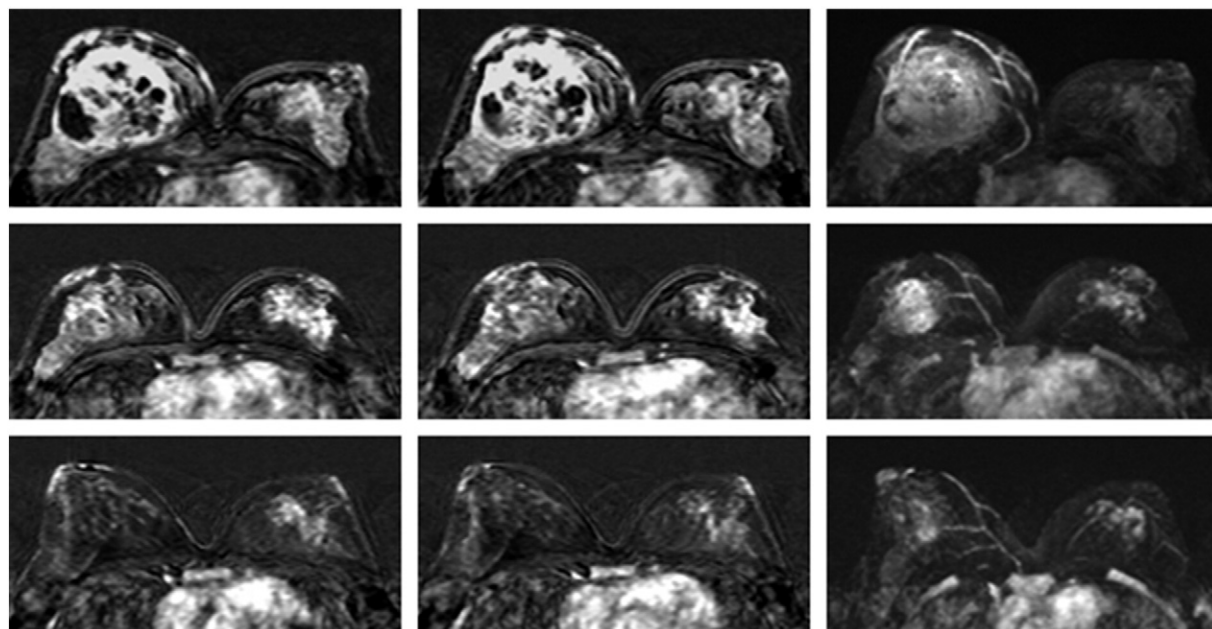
A 32-year-old woman with pCR after NAC. Before NAC, a 9.1-cm triple negative IDC in the right breast was noted. Upper panel: baseline MRI; middle panel: FU-1 MRI (after two AC); lower panel: FU-2 MRI (after four AC). The left and middle columns are two continuous subtraction images. The right column is the maximal intensity projection image. Note the strong background enhancement in the fibroglandular tissue of the left breast in the baseline MRI. The enhancement decreases in the FU-1 MRI and further decreases remarkably in the FU-2 MRI. The BPE was 60.0%, 46.3%, and 30.0% in baseline, F/U-1, and F/U-2 MRI, respectively.
